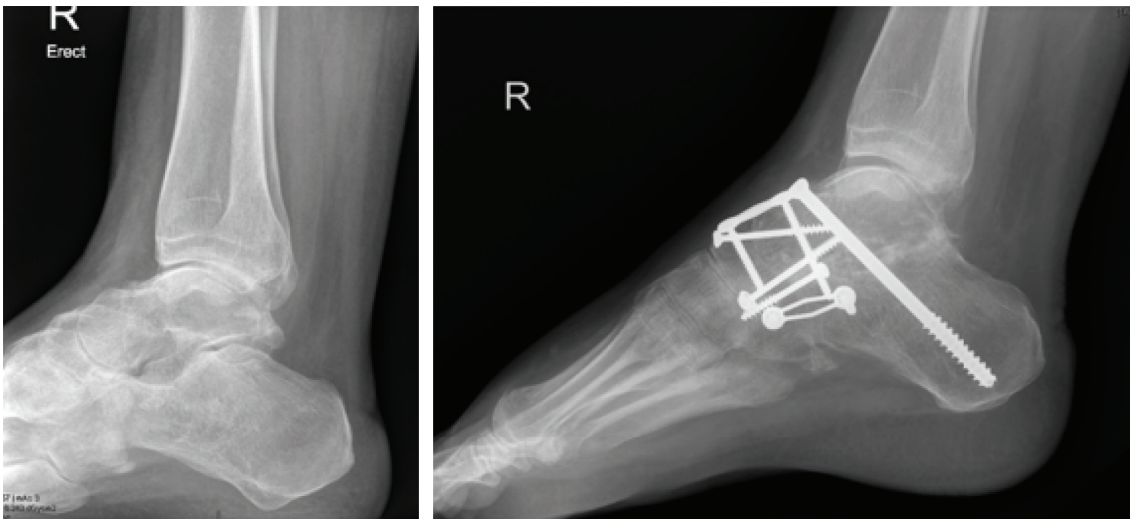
Lateral x-rays pre- and postoperative in a teenage boy with intellectual impairment and autism with unilateral cavovarus deformity having failed previous soft tissue releases and tibialis posterior tendon transfer; demonstrating hybrid fixation options, with compression screws and compression plating across the talonavicular and calcaneal cuboid joints.
